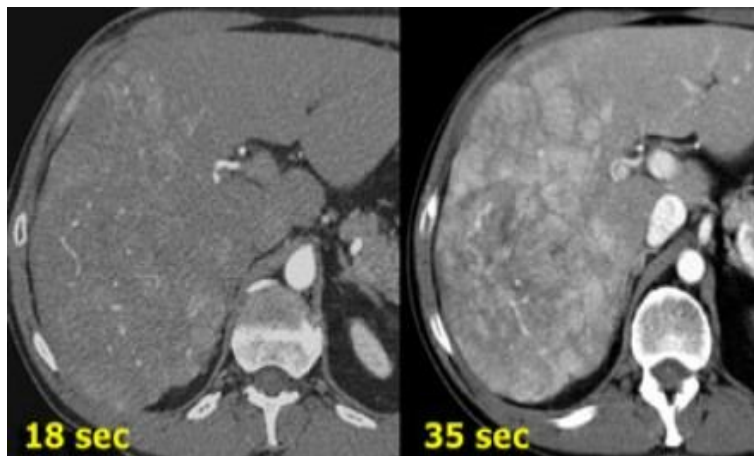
CT of the liver in the early arterial phase (left) and the late arterial phase (right). (Jorge and Soto Boston university .Radiology2002)
